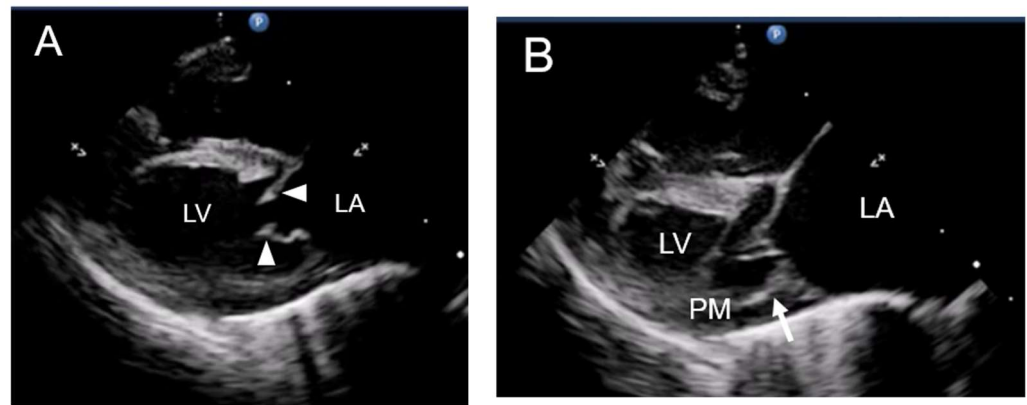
Two-dimensional echocardiographic images obtained from the right parasternal long axis view showing the left cardiac chambers and mitral valve in early diastole (A) and systole (B). (A) There is thickening and reduced opening of the mitral valve leaflets (arrowheads) in early diastole and (B) direct attachment of the posterior mitral valve leaflet to the papillary muscle (arrow). Severe left atrial enlargement is also evident. LA: left atrium; LV: left ventricle; PM: posterior papillary muscle.
